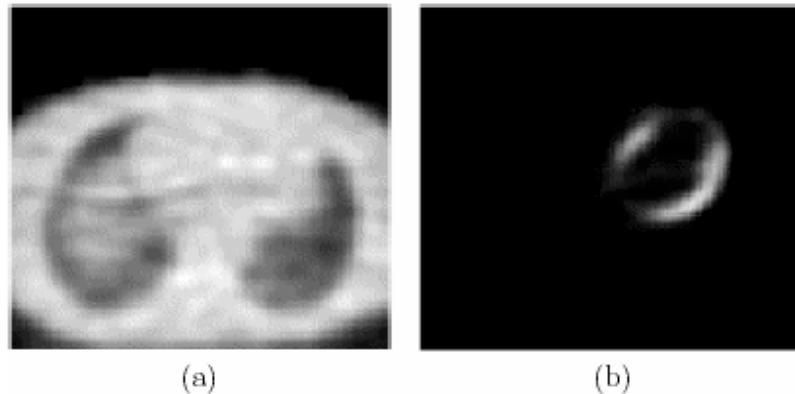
Images TEP de (a) transmission et (b) d'émission 18F-FDG [Mäkelä, 2001].
